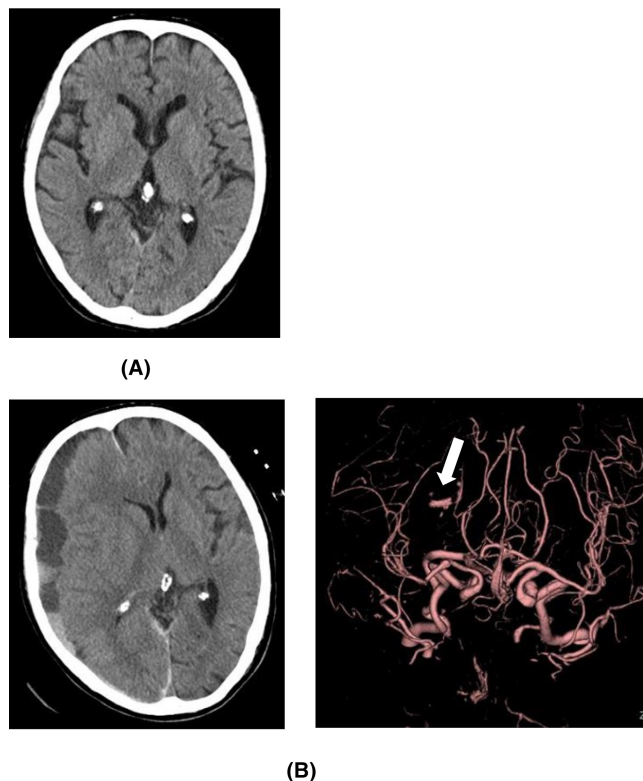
(A) Head computed tomography (CT) of Case 3 on admission, (B) Head CT and CT angiography of Case 3 on day 5. Arrow shows a traumatic aneurysm in the right posterior cerebral artery.
